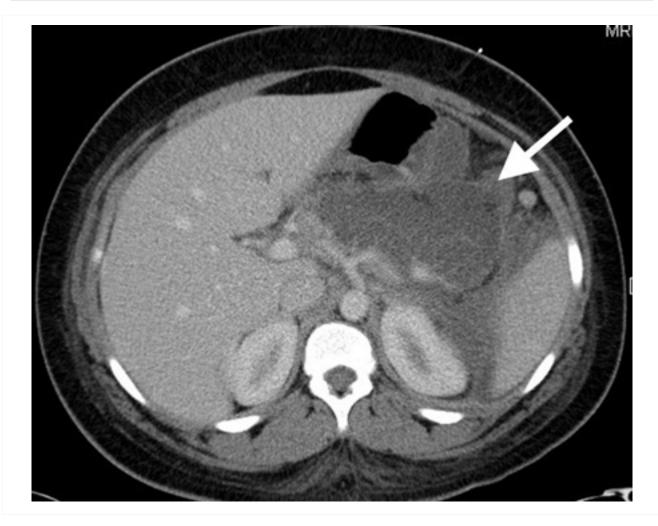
CT scan of teenage girl presenting with mid-epigastric abdominal pain as a result of gallstone pancreatitis. The large fluid collection in the pancreatic bed (white arrow) and lack of pancreatic enhancement suggest liquefactive necrosis of the pancreas
